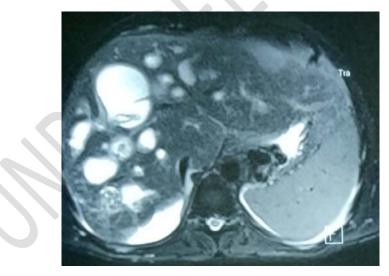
MRI showing post-operative consequences
